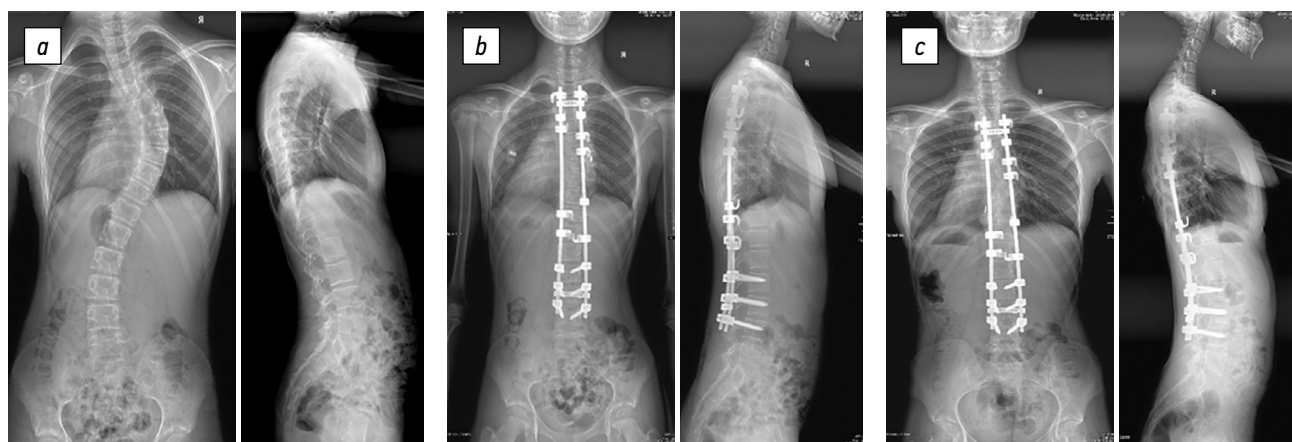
Radiographs of a 13-year-old patient in two views: *a* — preoperative image of the right-sided thoracic scoliotic deformity of IV degree ( $74^\circ$  according to Cobb) with lumbar anti-curvature ( $47^\circ$ ), with thoracic kyphosis of  $24^\circ$  and lumbar lordosis of  $67^\circ$ ; *b* — surgical correction of scoliotic deformity of the spine using hybrid fixation without ventral intervention results in main thoracic curve of  $30^\circ$ ; lumbar anti-curvature of  $10^\circ$ , thoracic kyphosis of  $18^\circ$ , and lumbar lordosis of  $60^\circ$ ; *c* — X-ray control 3 years after the surgery revealed main thoracic curve of  $46^\circ$ , lumbar anti-curvature of  $10^\circ$ , thoracic kyphosis of  $18^\circ$ , and lumbar lordosis of  $76^\circ$
